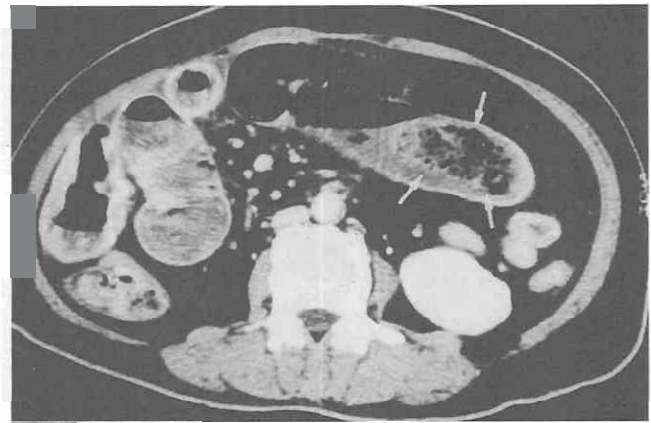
Intestinal obstruction caused by phytobezoar. CT scan shows an ovoid mass (arrows) containing mottled gas at the ileum along with diffuse small intestinal dilatation due to obstruction.
